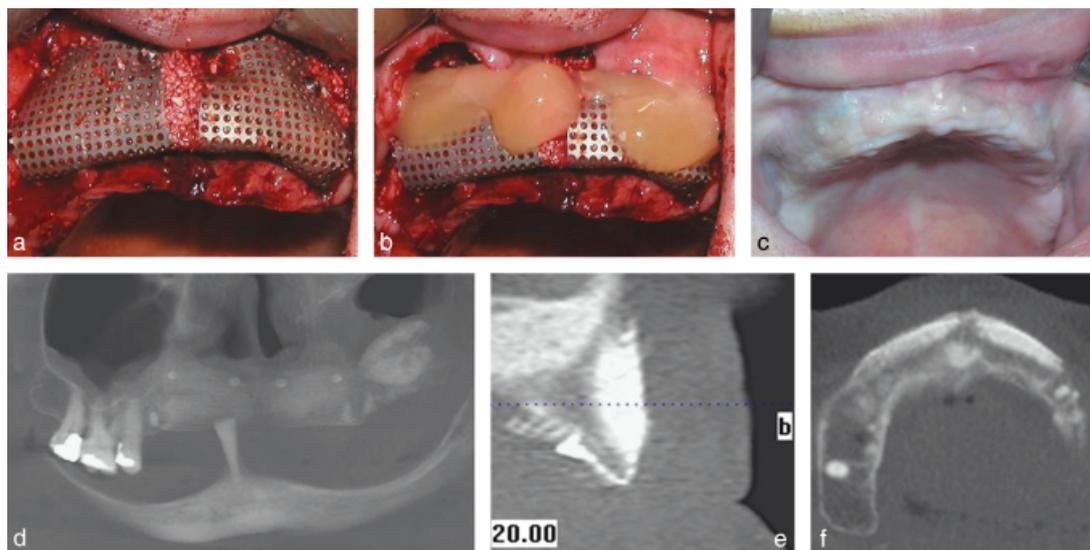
(a) Ti-mesh adapted on the maxillary residual ridge. (b) Placement of platelet-rich plasma gel over the Ti-mesh. (c) Healed alveolar ridge after 6 months without Ti-mesh exposition. A panoramic radiograph (d), a sagittal CT section (e), and a transverse CT section (f) of the treated site 6 months after the intervention showing the alveolar ridge augmentation achieved.
